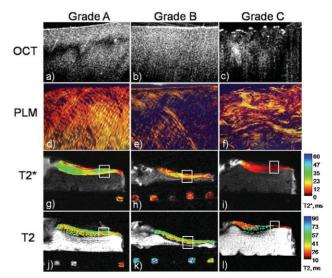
Comparison of OCT grade to PLM and MRI. a–c) Representative OCT images of cores with grades A–C. d–f) PLM images from OCT grades A–C demonstrating increasing matrix degeneration. g–i) UTE-enhanced T2\* images showing decreasing relaxation time with increasing OCT grade. j–l) T2 images demonstrating increasing T2 relaxation time with increasing OCT grade.
